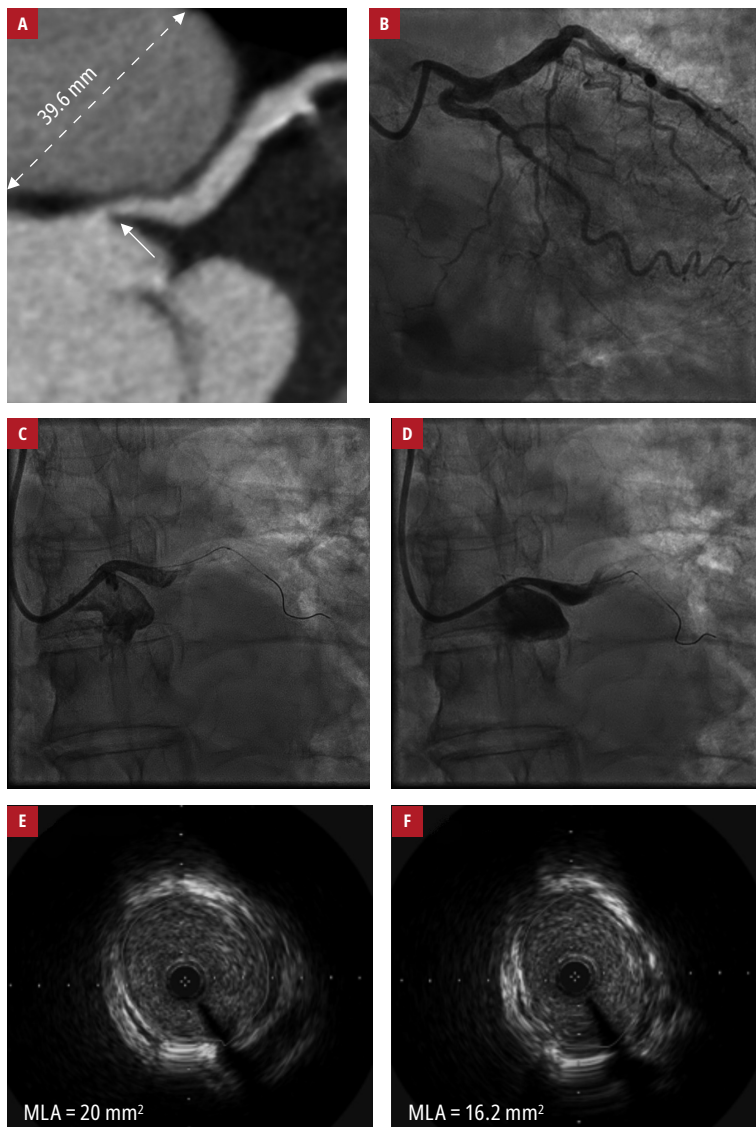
A – multidetector computed tomography showing ostial and focal left main coronary artery (LMCA) stenosis (60%; arrow) and dilated pulmonary artery trunk; B – left coronary angiogram; C, D – diastolic and systolic filling of the LMCA, respectively; E, F – intravascular ultrasound images of the ostial LMCA during diastole and systole, respectively
